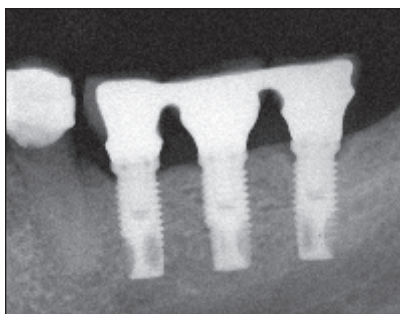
Periapical radiograph at 3-year follow-up with implant in function.
